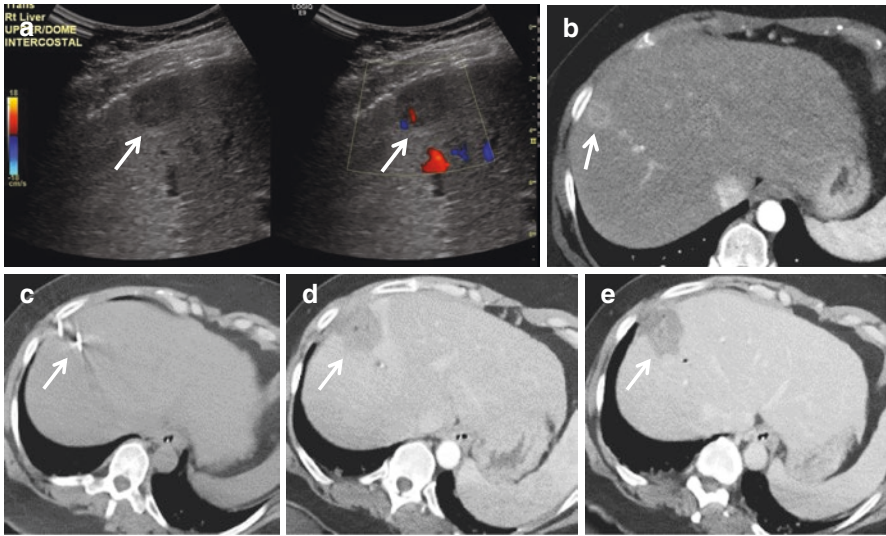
Small mass-forming intrahepatic cholangiocarcinoma (iCCA) evaluated with ultrasound and CT and treated with percutaneous microwave ablation (MWA). (a) Grayscale and color Doppler ultrasound shows a small, well-circumscribed hypoechoic mass with mild vascularity (white arrow). (b) The mass shows peripheral enhancement on contrast-enhanced CT (white arrow). (c) The mass was treated with percutaneous microwave ablation using two microwave antennae (white arrow). (d, e) Immediate postablation contrast-enhanced CT shows the hypoechoic ablation zone encompassing the tumor without any residual enhancing tumor on (d) arterial or (e) portal venous phase (white arrow). CT computed tomography
